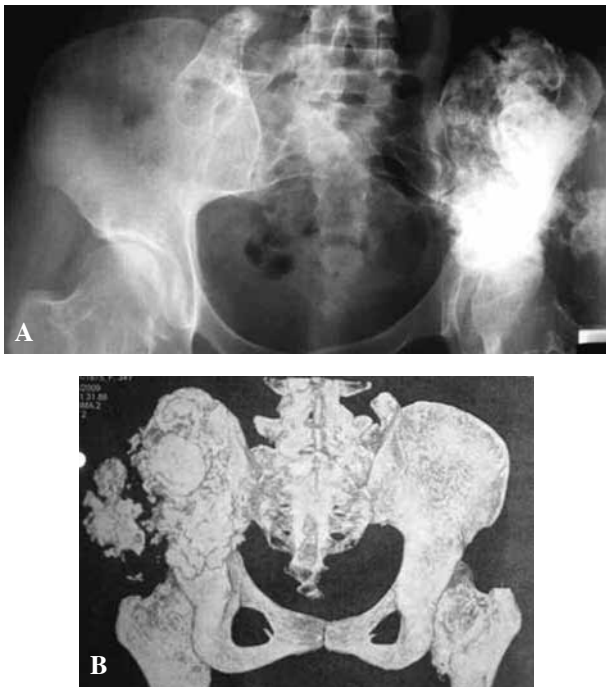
and 2B. — Preoperative radiographs and CT scans of case 2. Images suggest a mass involving the left iliac bone and sacroiliac joint as well as the gluteal muscles.
